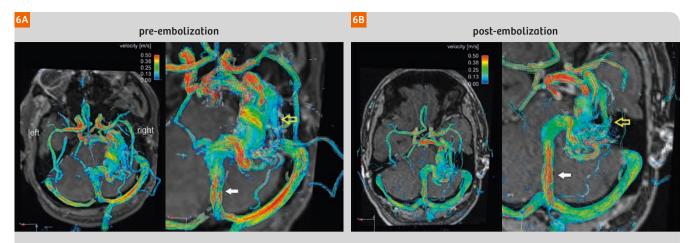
Intracranial 4D Flow MRI for the assessment of arterial and venous cerebrovascular hemodynamics. 3D blood flow visualization using time-integrated 3D pathlines in a 29-year-old male patient with a large unruptured AVM centered in the right mesial temporal lobe with compact nidus prior to treatment (6A) and following invasive staged embolization therapy (6B: DSA guided endovascular superselective occlusion of AVM feeding arteries with nidal penetration). Complex arterial feeding and convoluted hemodynamics as well as differences in pre- and post-embolization vascularization and hemodynamics are clearly visible. Staged embolization resulted in compaction of the AVM with reduced blood flow velocities (yellow arrows) and reduced flow velocities for venous drainage (white arrow).
